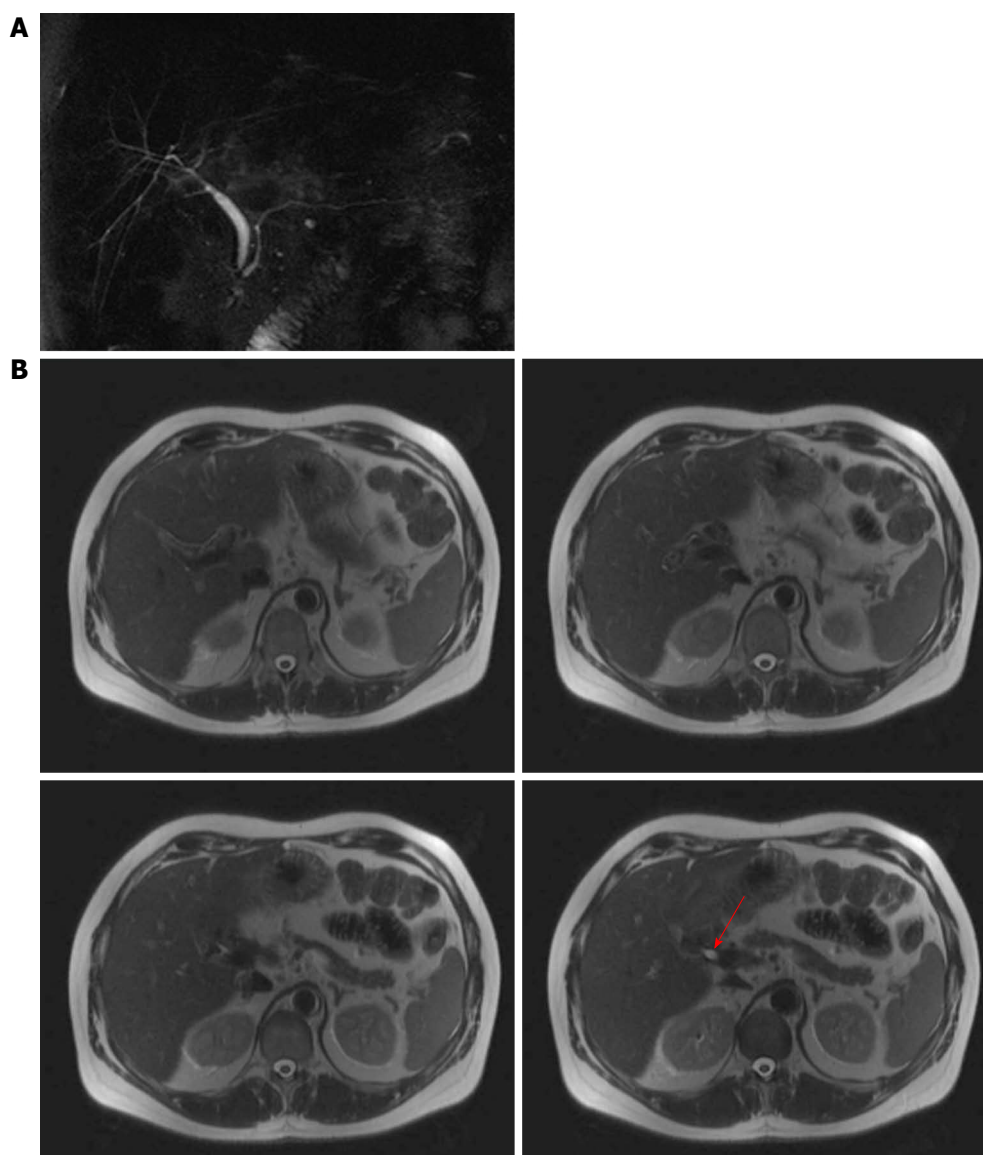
Duct-to-duct anastomosis. A: Single-shot thick-slab magnetic resonance cholangiogram shows a choledocho-choledocho anastomosis with a discrepancy of caliber between donor and recipient choledochi; B: Axial single-shot T2-weighted images demonstrate the anastomotic patency (red arrow).
